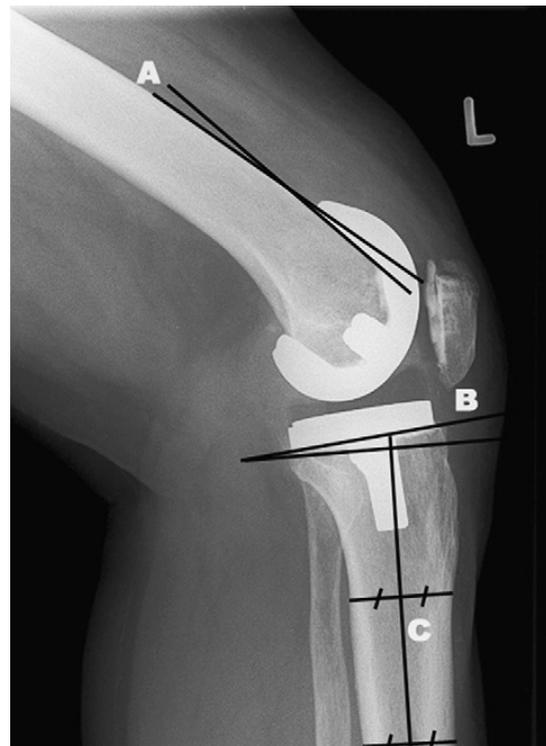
Analyses of the sagittal alignment on postoperative short-leg-length lateral radiograph at 30° of knee flexion: the sagittal femoral component angle (angle A) and the sagittal tibial component angle (angle B) (ie, the tibial slope). The slope of the tibial component (B angle) is measured with reference to the proximal anatomic axis (C).
